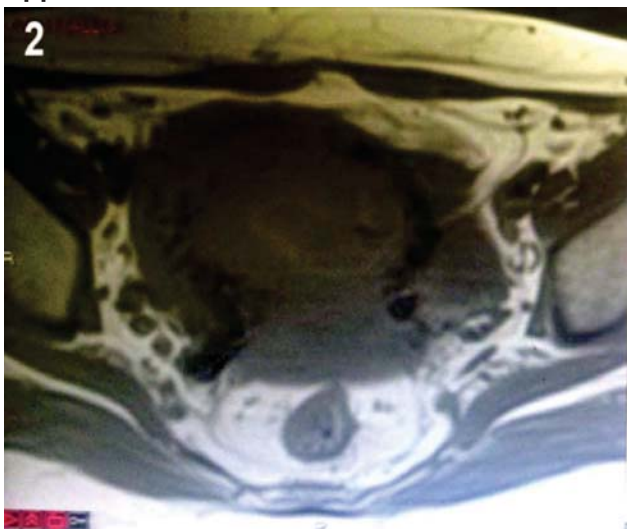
Multiple flow voids in T1 MRI.
